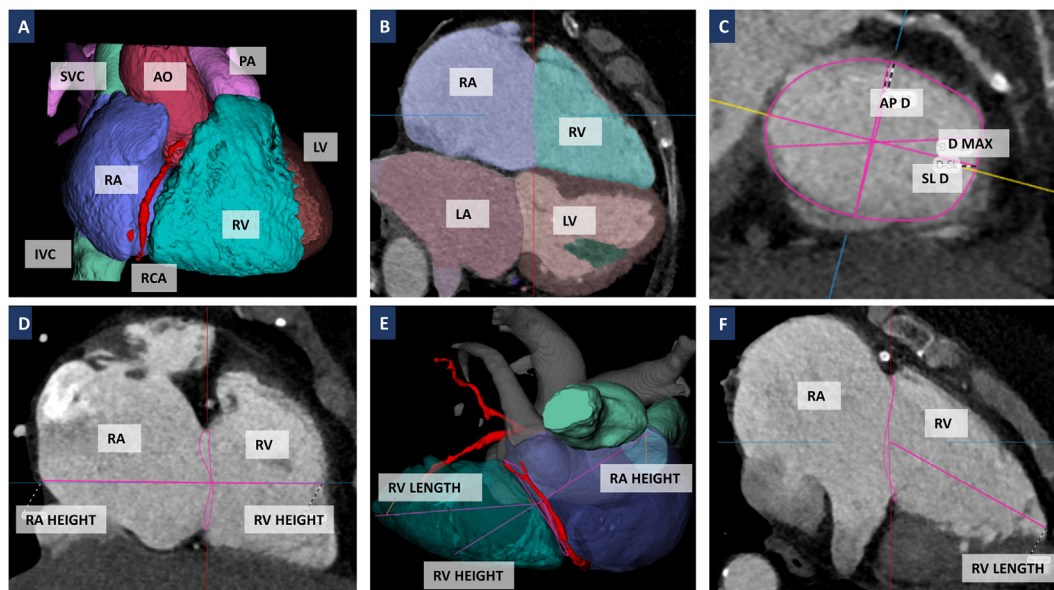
Three dimensional (1A, 1E) and two dimensional (1B-1D, 1F) CT reconstructions with fully automated segmentation of all cardiac chambers and adjacent vessels. The study specific protocol included automated measurement of various parameters across multiple phases, including atrial and ventricular volumes and areas (1A-1B), TA dimensions (1C), as well as RA and RV heights (1D-1E) and RV length (1E-1F). Ao = Aorta, AP = Anteroposterior, D = Diameter, LA = Left Atrium, LV = Left Ventricle, PA = Pulmonary Artery, RCA = Right Coronary Artery, SVC = Superior Vena Cava.
